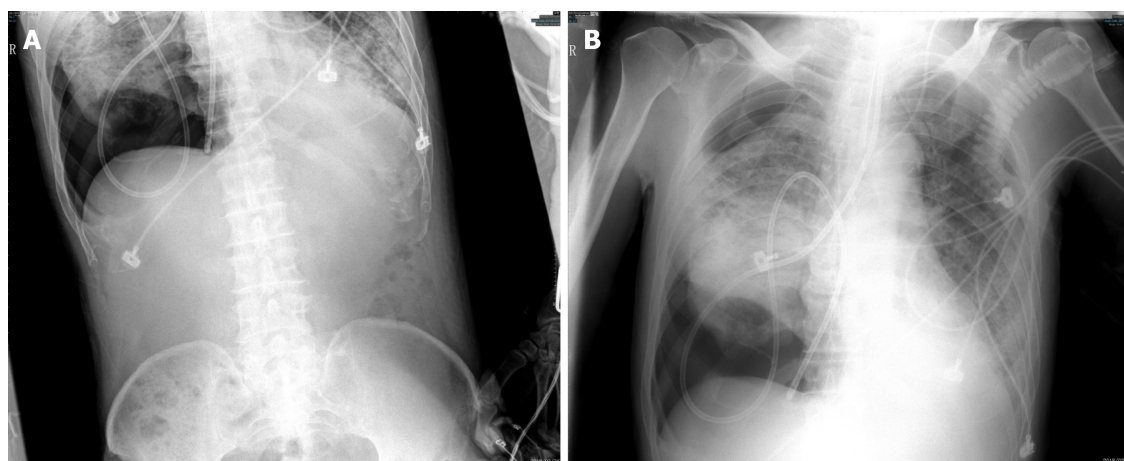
X-ray after placement of the feeding tube. A: Abdominal X-ray shows there is no jejunal tube in the abdomen, and the jejunal tube is on the diaphragm; B: Chest X-ray shows the jejunal tube is in the chest.
